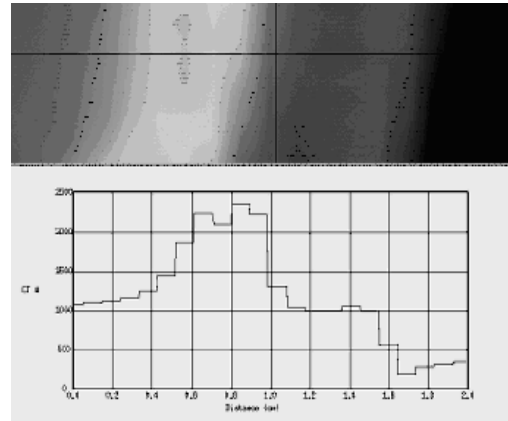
A CT number profile of the outer skull was used to determine a threshold of 1600 HU for all autocontouring of the outer skull.
